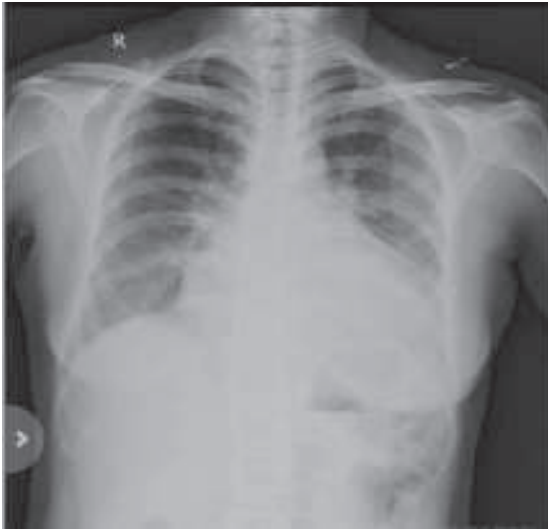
Chest X-ray Suggestive of Cardiomegaly
